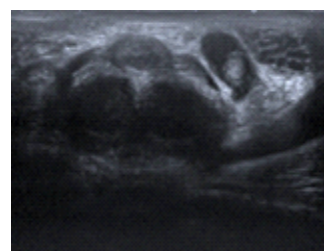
Ultrasound demonstrating echogenic intraluminal thrombus in the left spermatic vein.
